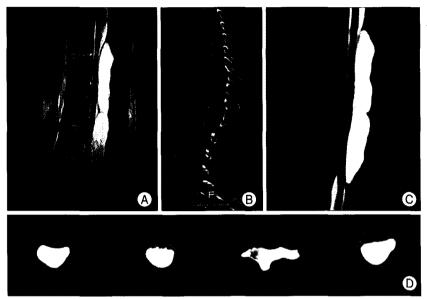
Preoperative image findings. Sagittal T2-weighted magnetic resonance image (MRI) of thoracolumbar spine reveals a septated cystic lesion at the posterior extradural space at the T10-L2 level with high signal change in spinal cord (A). Six-hour delayed myelo computed tomography (CT) reveals no cerebrospinal fluid (CSF) communication between intradural subarachnoid space and cyst (B). Sagittal (C) and 3 mm thin slice axial (D) constructive interference in steady state magnetic resonance imaging (CISS-MRI) also reveal no cerebrospinal fluid (CSF) communication between intradural subarachnoid space and cyst.
